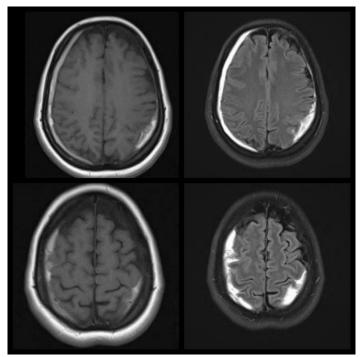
Brain MRI: T1 and T2
